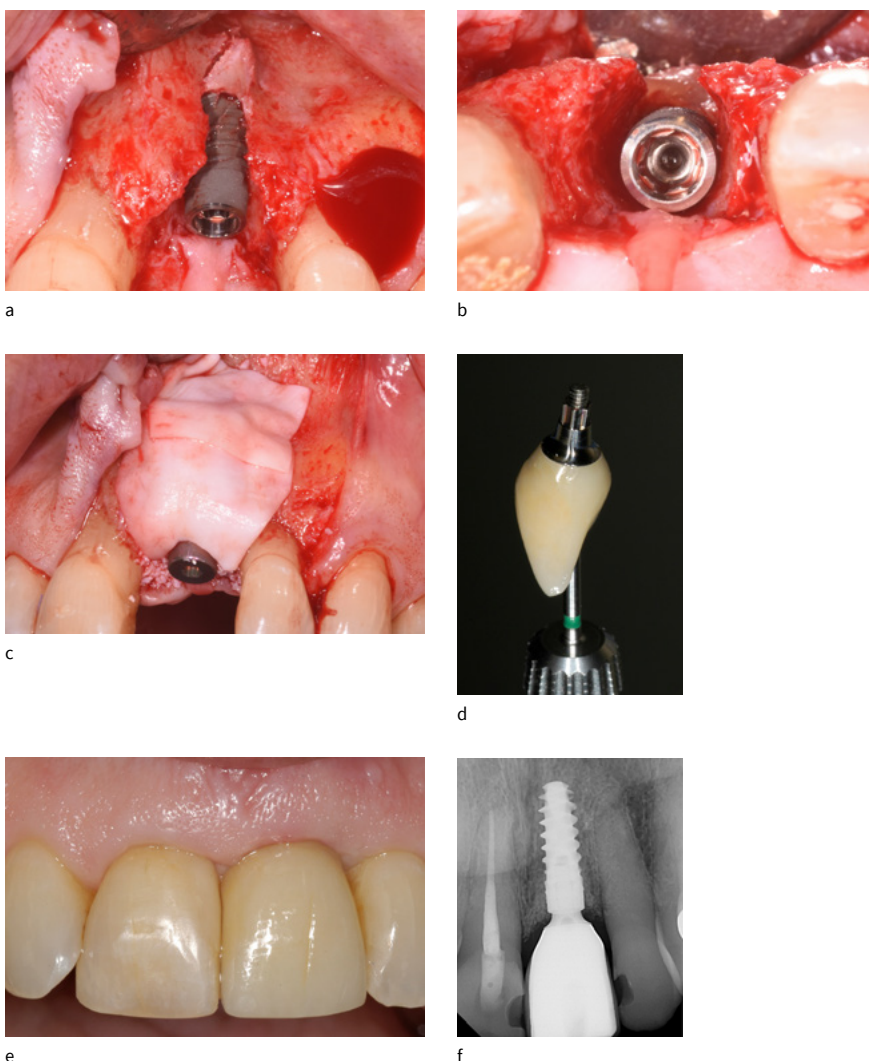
Implant with deep apical threads used to optimize primary stability despite the lack of coronal-bone contact in this early (6-week post-extraction) placement with simultaneous augmentation. a: Surgical placement with apical stabilization. b: Occlusal view showing no coronal retention. c: Grafting. d: Final screw-retained crown. e: Final restoration in place. f: 1 year post-op radiograph
